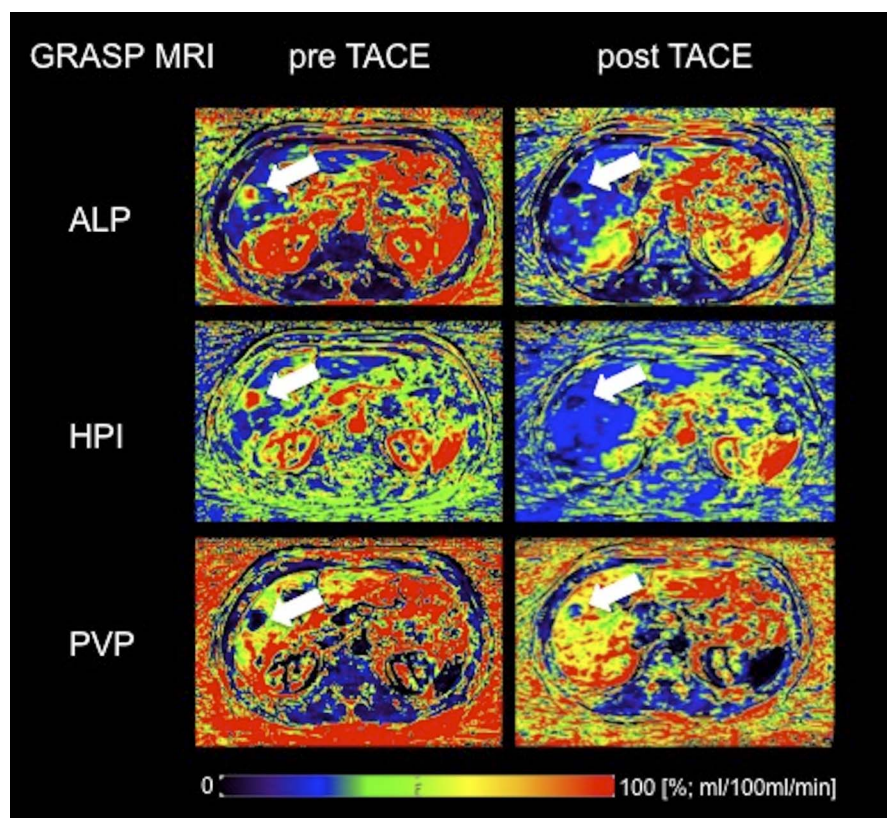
Comparison of perfusion maps derived from GRASP MRI before and after TACE. The target lesion (arrow) shows distinct changes in perfusion characteristics (decrease in ALP and HPI, relative increase in PVP) after treatment. GRASP MRI, golden-angle radial sparse parallel MRI; TACE, transarterial chemoembolization; ALP, arterial liver perfusion [mL/100 mL/min]; HPI, hepatic perfusion index [%]; PVP, portal liver perfusion [mL/100 mL/min].
